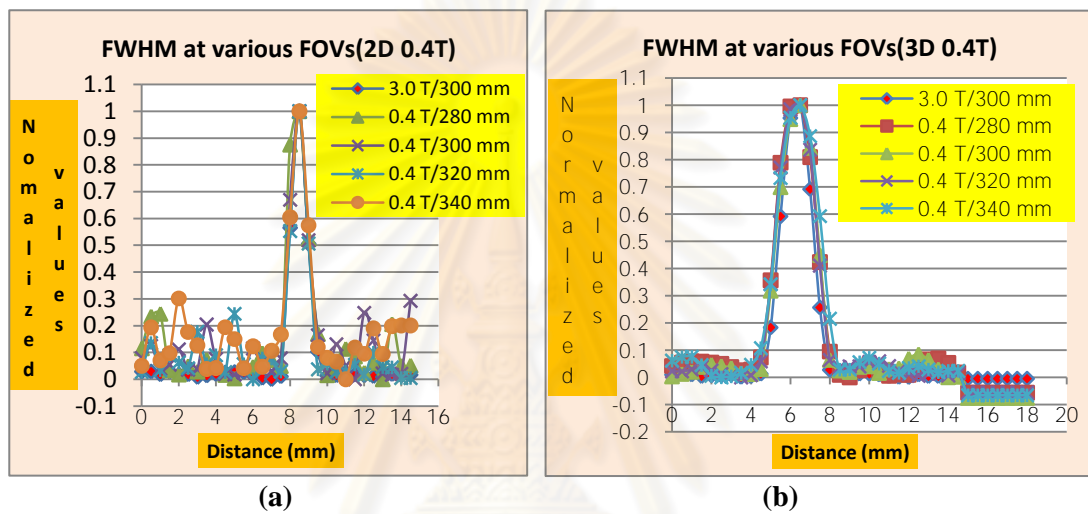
FWHM at various FOVs of 2D (a) and 3D (b) images at MRI 0.4 T compared to FOV 300 mm at MRI 3.0 T
